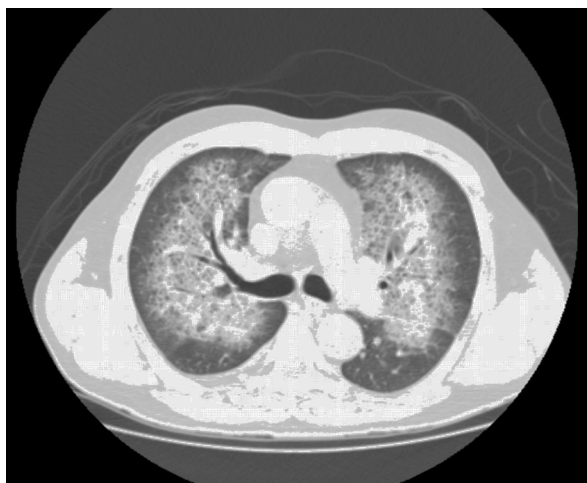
Non-contrast thoracic CT scan: Bilateral central parenchymal infiltrates with a "crazy paving" pattern.
